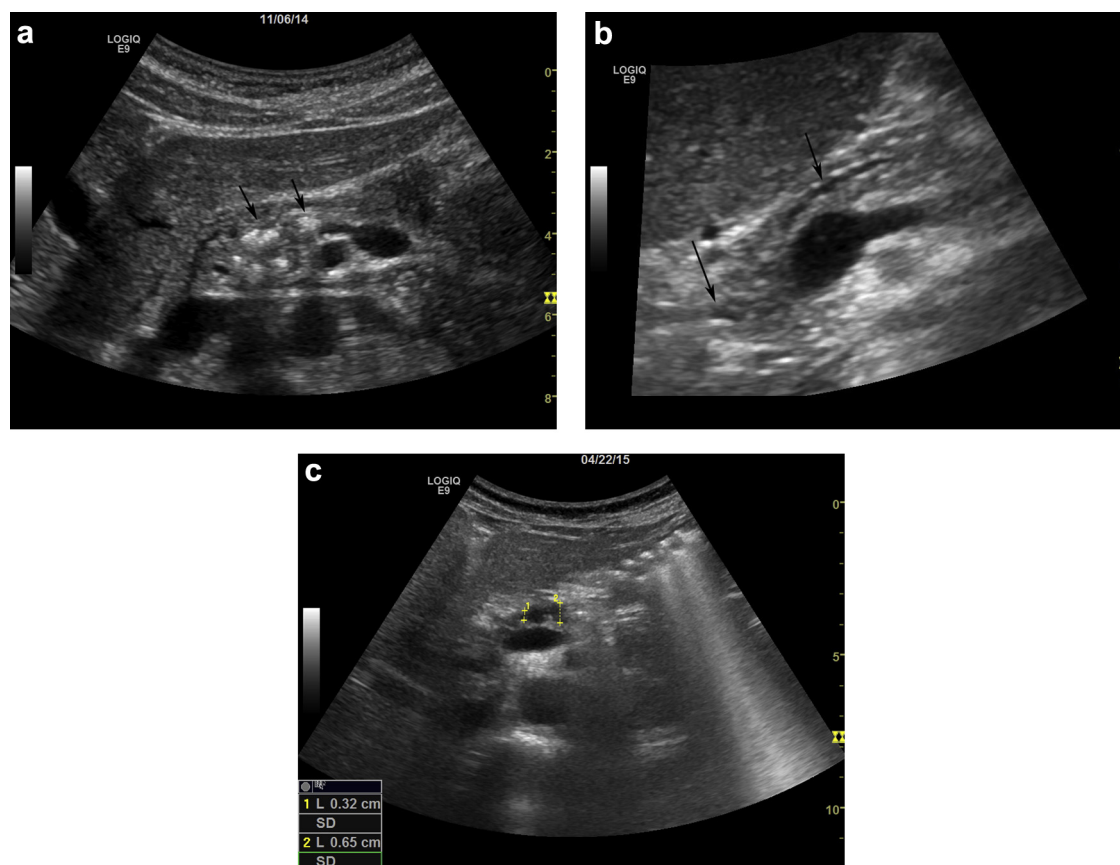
Images revealing different ultrasound-detected features of chronic pancreatitis. (a) Ultrasound image of several large, shadowing calcifications in the head and body of the pancreas. (b) Ultrasound image revealing a large, shadowing calcification in the main pancreatic duct (left arrow), with dilated duct in pancreatic body (right arrow). (c) Ultrasound image revealing chronic dilation and caliber variations in the main pancreatic duct in the body of the pancreas.
